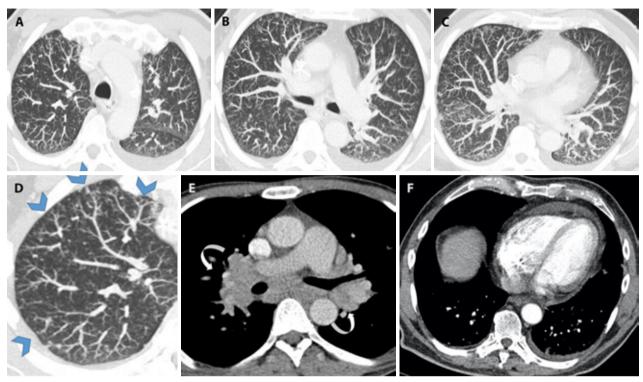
A 50-year-old male comes to our ED with a non-productive cough, dyspnoea for minimal effort, and marked asthenia. Axial MIP reconstructions (a-b-c-d) show better the vascular tree-in-bud pattern (blue arrowheads). Contrast-enhanced CT scan with a mediastinal window shows large bilateral lymphadenopathies (white arrows in "e"); right-heart enlargement and pericardial effusion are also visible (f).
